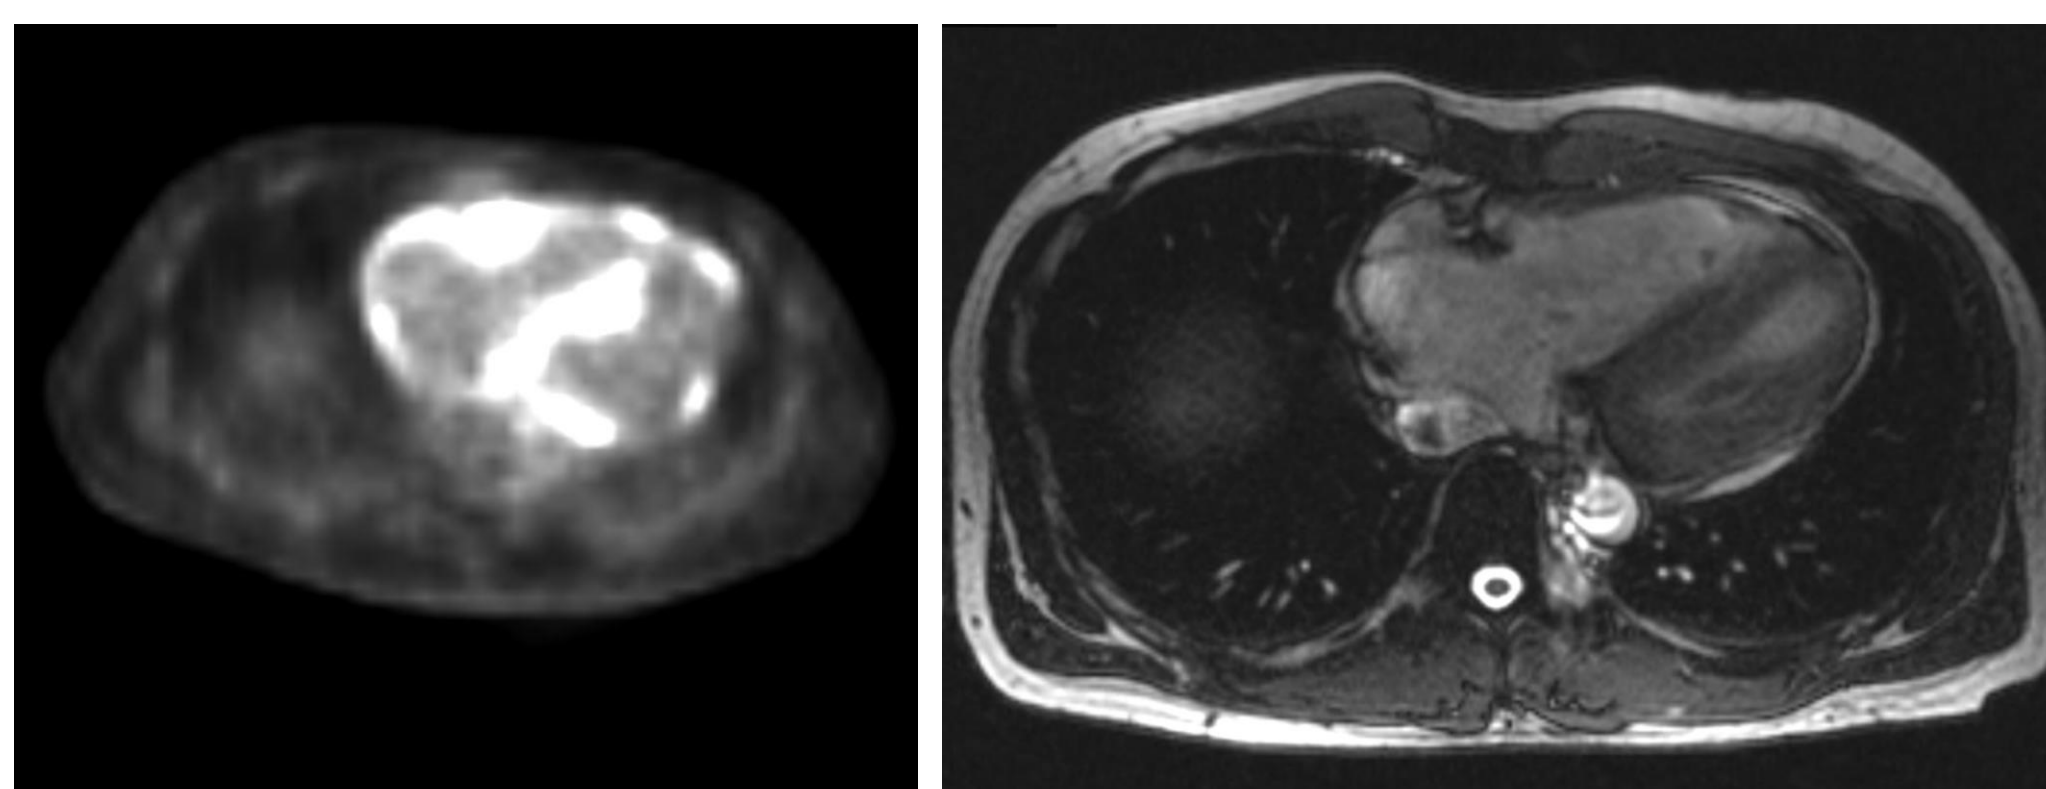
PET-CT (left) showing cardiac hyperenhancement, and cardiac MRI (right) showing delayed enhancement; both findings are consistent with cardiac inflammation/scar.
